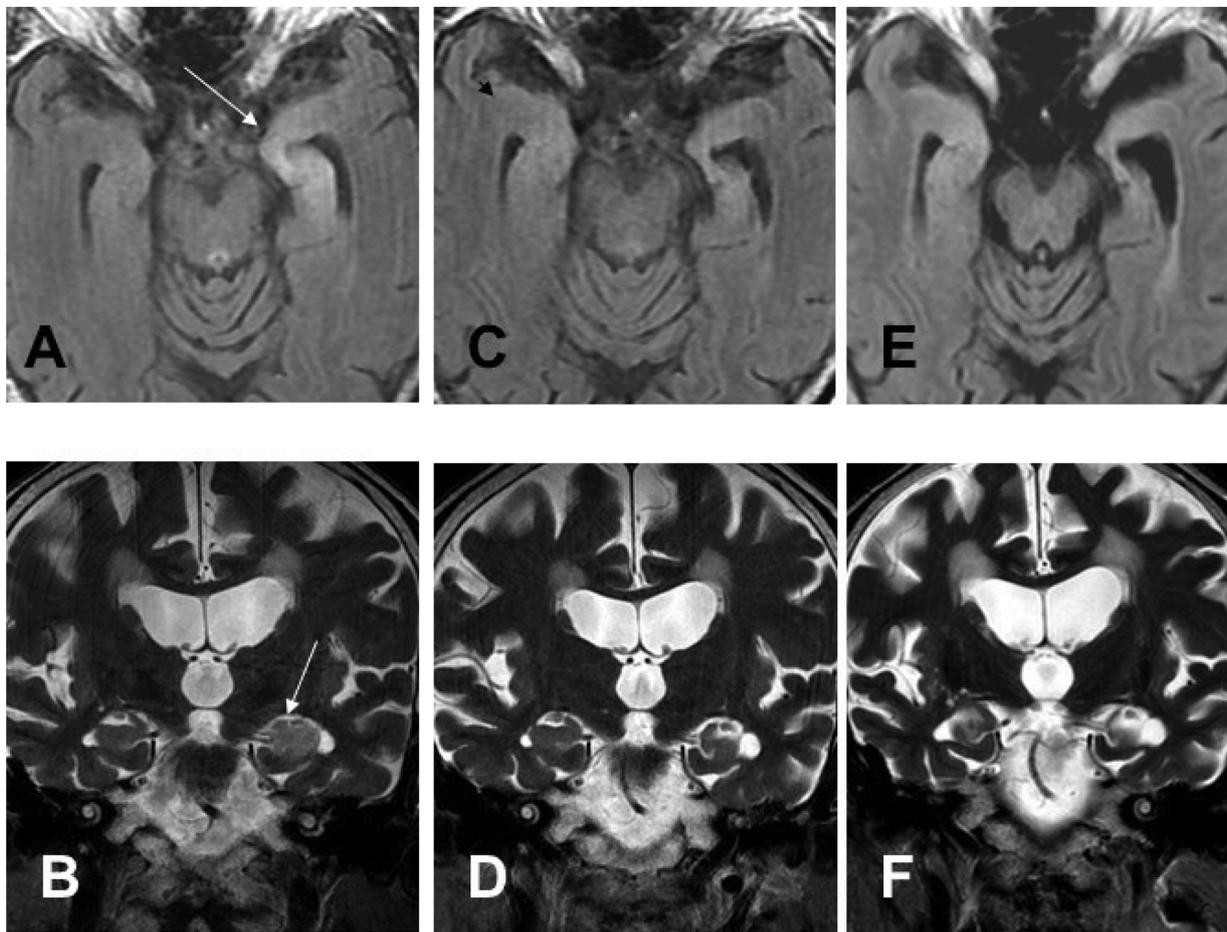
MRI scans at the onset of the limbic encephalitis and during the follow-up.
